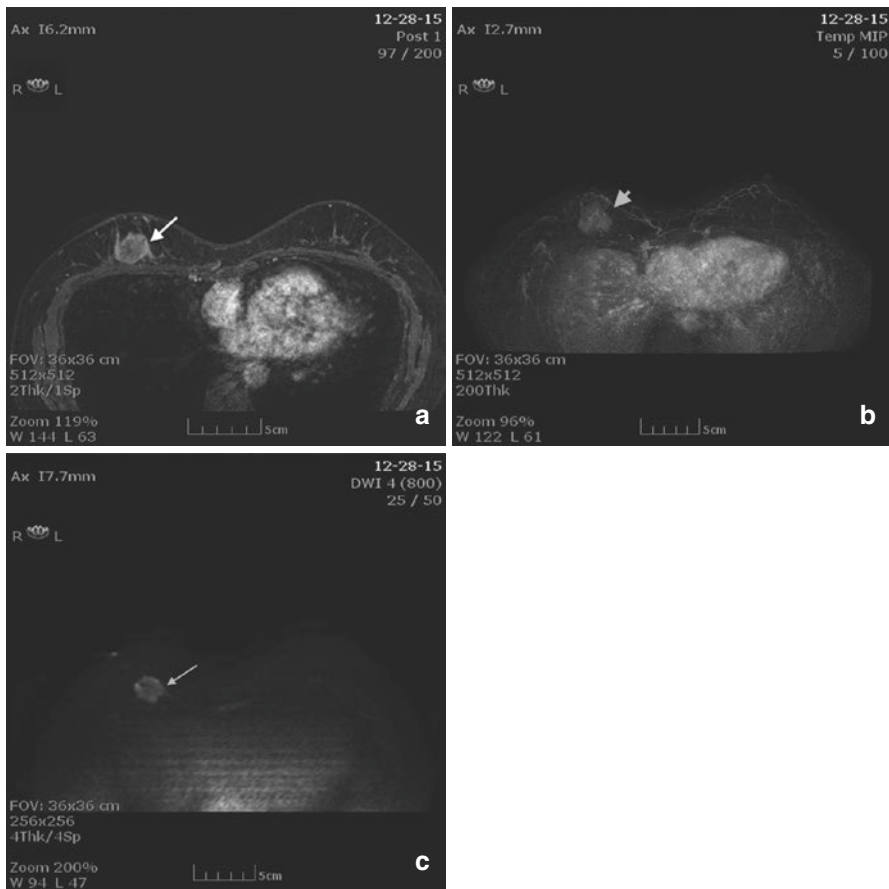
(a) Axial T1 post contrast image demonstrates a round rim enhancing mass with an irregular border (*arrow*). (b) MIP image demonstrates enhancement within the mass (*arrowhead*). (c) DWI image demonstrates bright signal within the mass indicating restricted diffusion (*arrow*)
